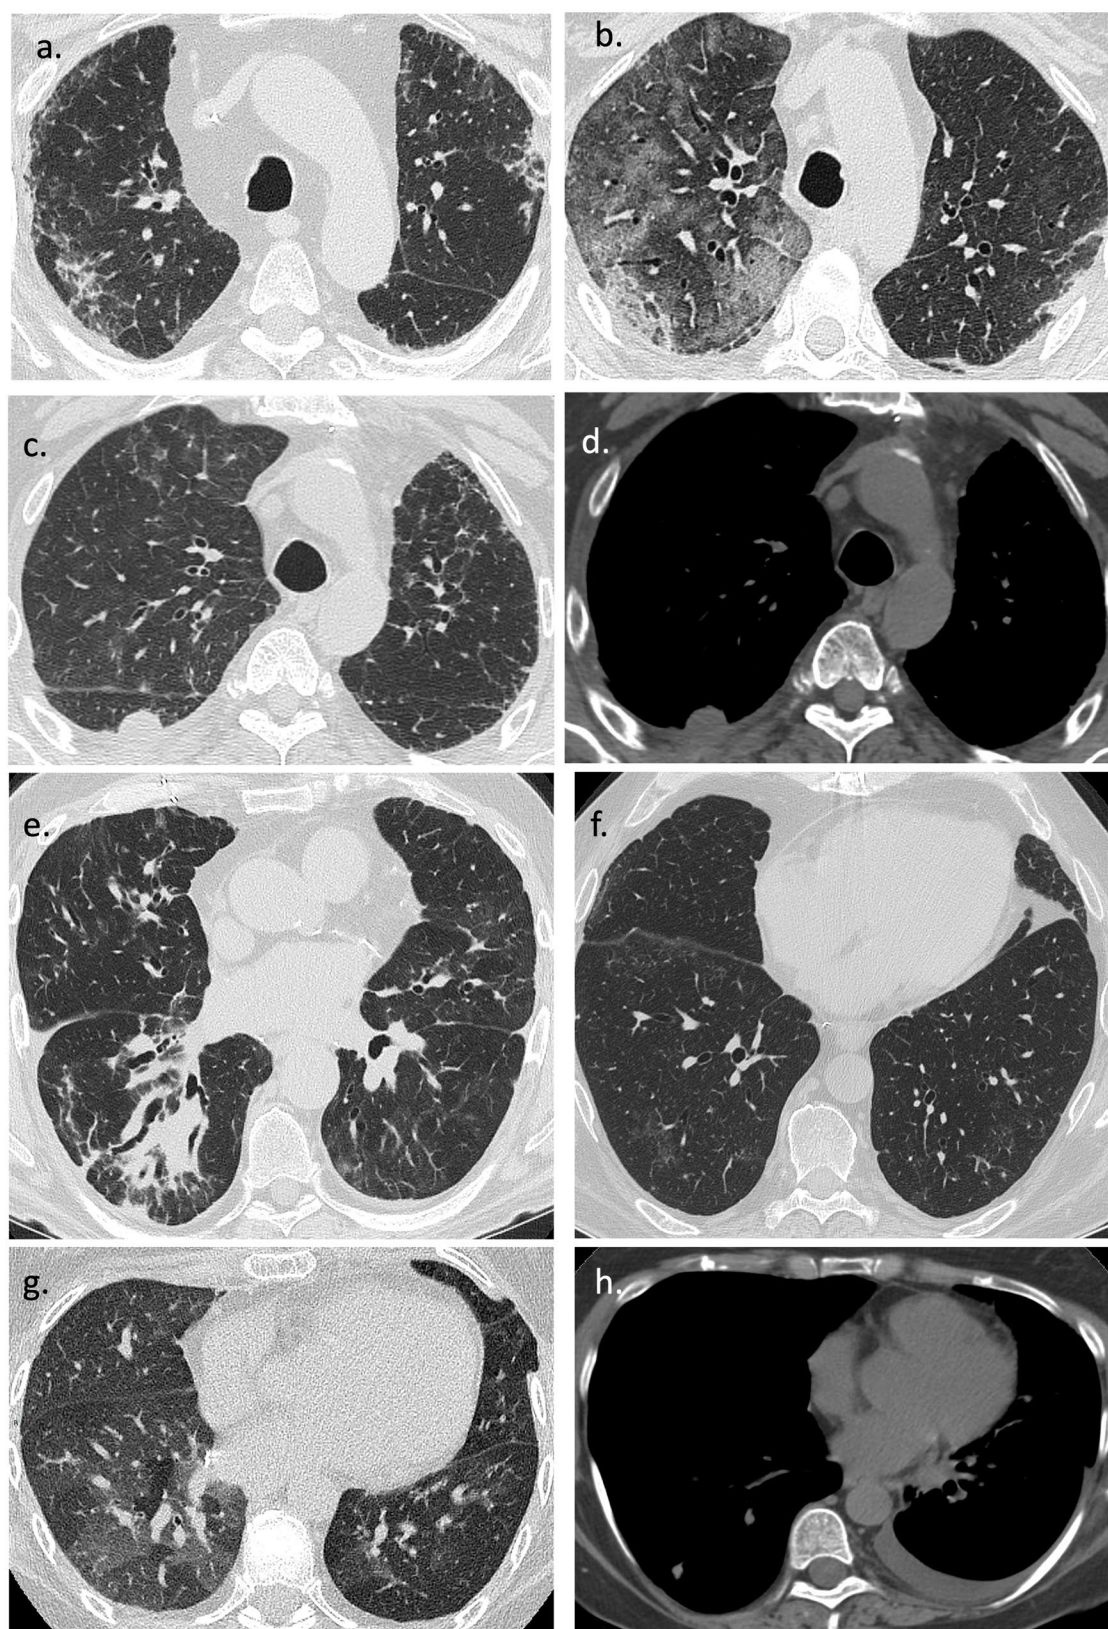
The main radiological features of acute rejection on high-resolution CT (HRCT) are as follows: (A) Bilateral irregular subpleural septal thickening. B Subpleural septal thickening associated with areas of ground-glass opacity on the right lung. C, D. Smooth septal thickening in lung parenchyma reconstructions and enlarged lymph nodes in the mediastinum. E Peribronchovascular consolidations. F Bilateral pulmonary micronodules. G Areas of air trapping on expiratory scans. H Left pleural effusion
